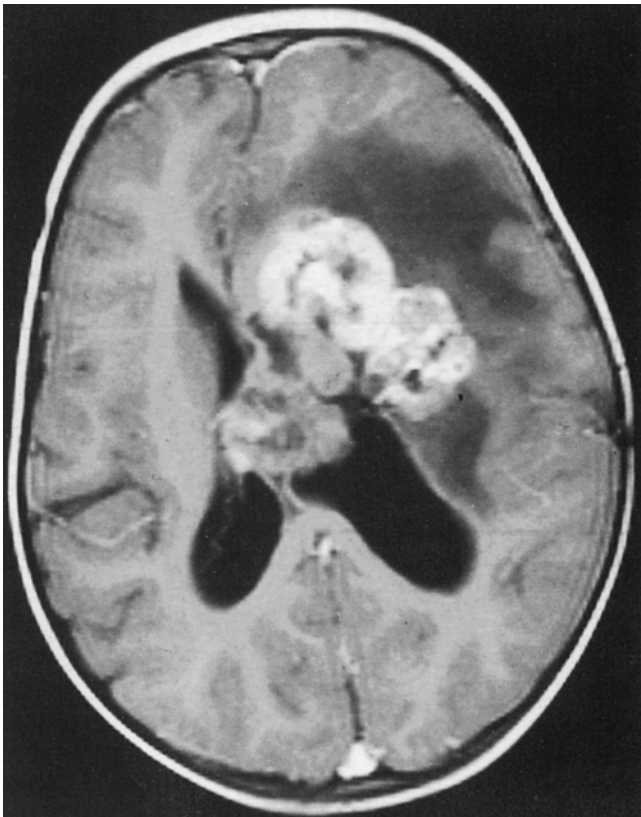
Axial T1-weighted MRI with gadolinium showing a large partially cystic, enhancing tumor involving the parenchyma and with extension into the lateral ventricle. The associated edema is characteristic of a malignant tumor
